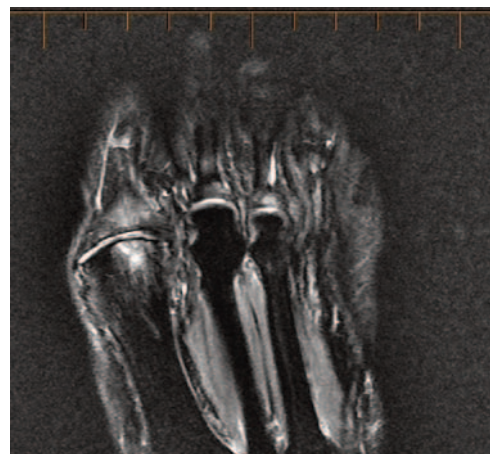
MRI reveals subchondral cystic changes and marrow edema associated with an OCD.
